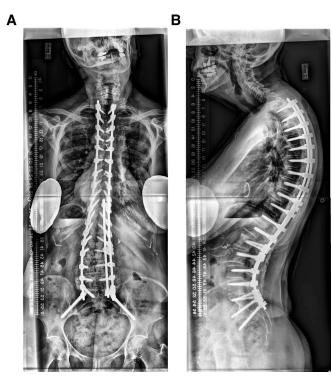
(A) Case example: baseline full standing coronal radiograph, (B) case example: baseline full standing lateral radiograph.
